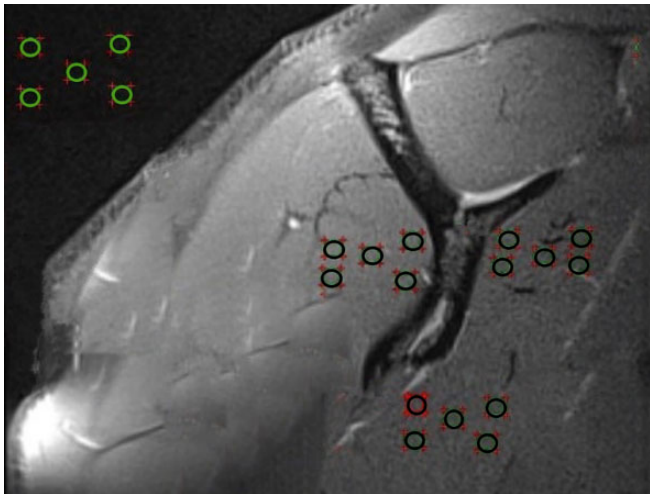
Determination of the signal-to-signal ratio of the subscapularis muscle on magnetic resonance imaging.
